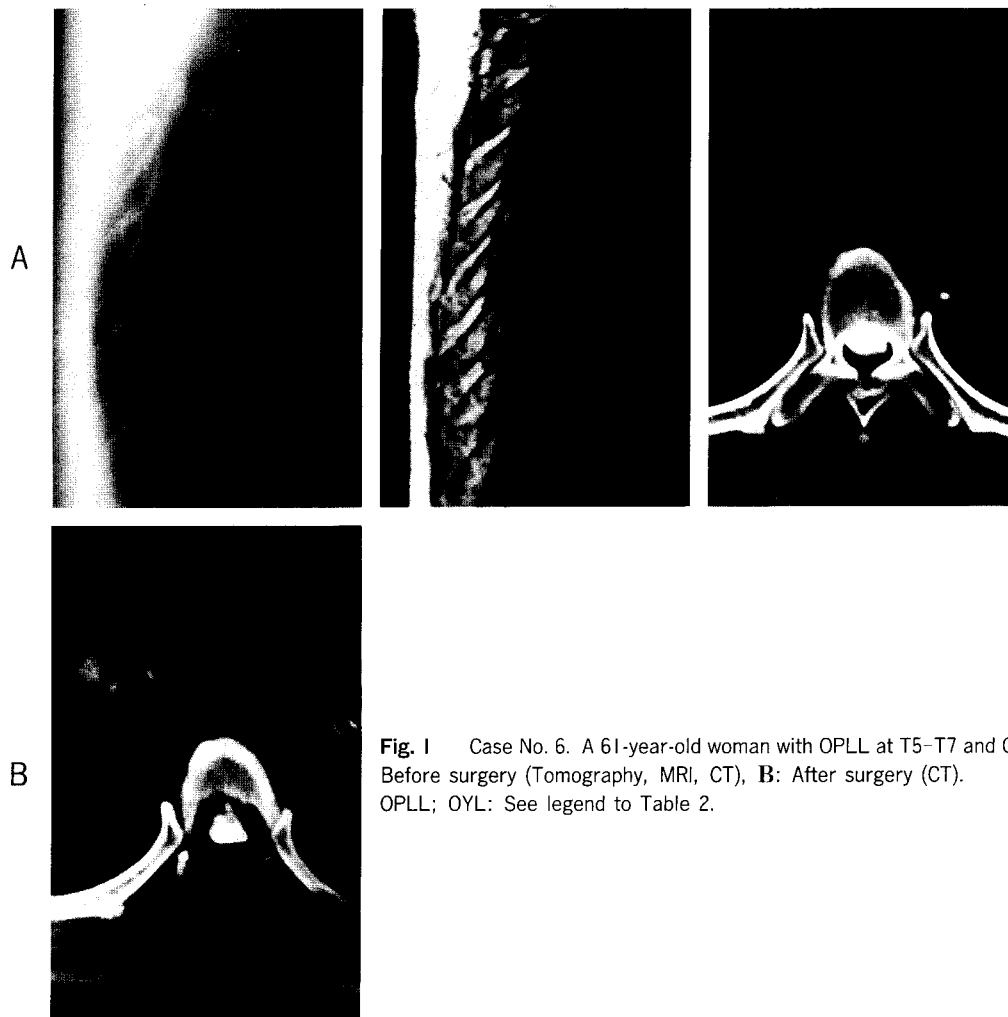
Case No. 6. A 61-year-old woman with OPLL at T5-T7 and OYL at T6-T11. A: Before surgery (Tomography, MRI, CT), B: After surgery (CT). OPLL; OYL: See legend to Table 2.
